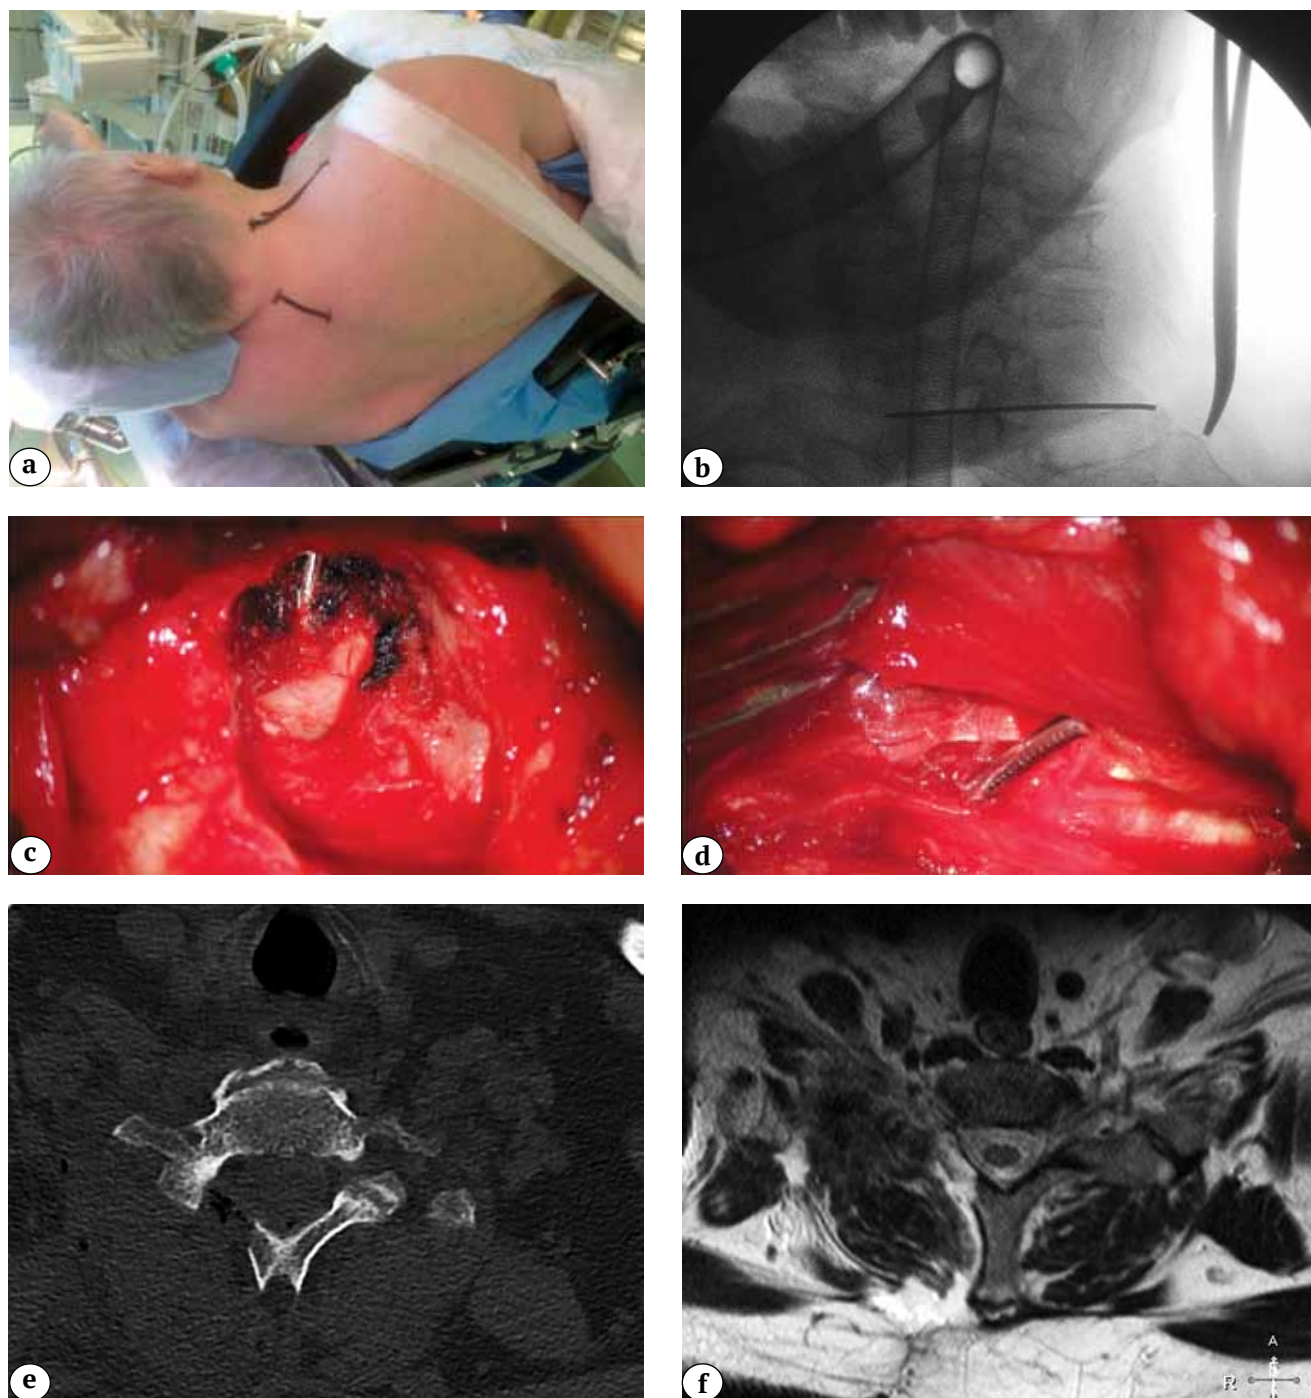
Procedure stages and postoperative X-ray control:
